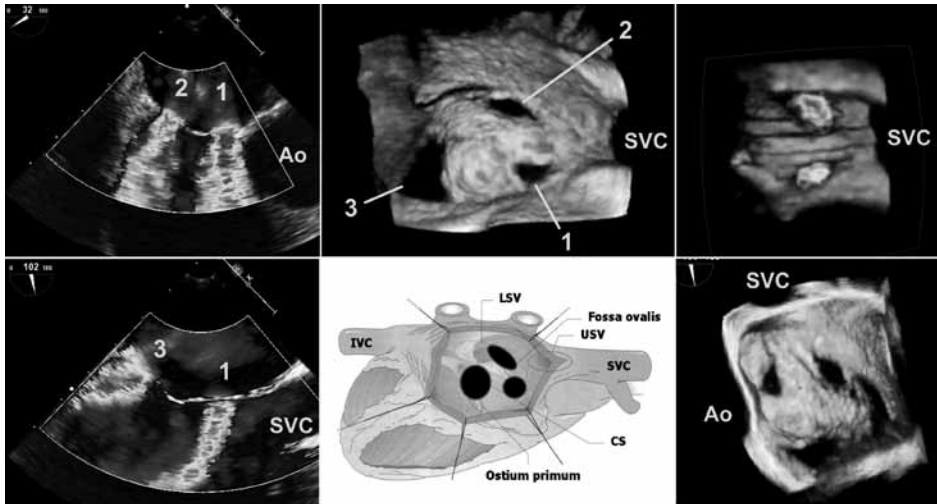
Example of 2D TEE and RT3D TEE representation of a multifenestrated ASD. Because 2D TEE showed two defects in the 32° rotation (top left) and two defects in the 102° rotation (bottom left), there had to be at least three defects that could not be visualized in one 2D image plane. The RT3DE en face view from the right atrium (top middle) and from the left atrium to the interatrial septum (IAS) (bottom right) clearly visualized the orientation of the three defects to each other as well as the location within the IAS and the spatial relation to surrounding cardiac structures. RT3D color Doppler en face view from the right atrium clearly identifies the flow passing through the three defects (top right). Defect 1 (1) is located anterior-superior, defect 2 (2) posterior-superior, and defect 3 (3) anterior-inferior. The RT3DE en face view from the right atrium to the IAS shows the location of the three defects on a nonplanar, domed IAS which makes 2D representation and planimetry of each defect very difficult (top middle). Ao aortic root, SVC superior vena cava, IVC inferior vena cava, LSV lower sinus venosus, USV upper sinus venosus, CS coronary sinus.
